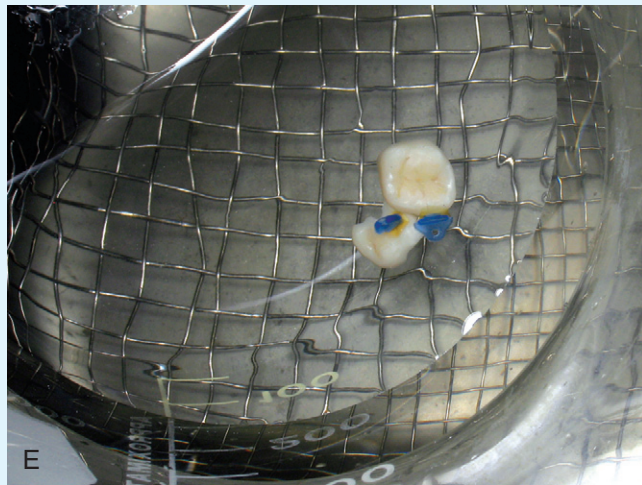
cont'd E, Ultrasonic cleaning. F, Pin tweezers holding the Griptab during silanation of the restoration. G, Placement of the Wave-Wedge with the pin tweezers. H, Interdental papillae protected with Wave-Wedges of different sizes. They also control the flow of expressed cement, aiding in cleanup. I, Minimal interproximal cement was present once the Wave-Wedges were removed. J, Completed restorations immediately post-cementation.
